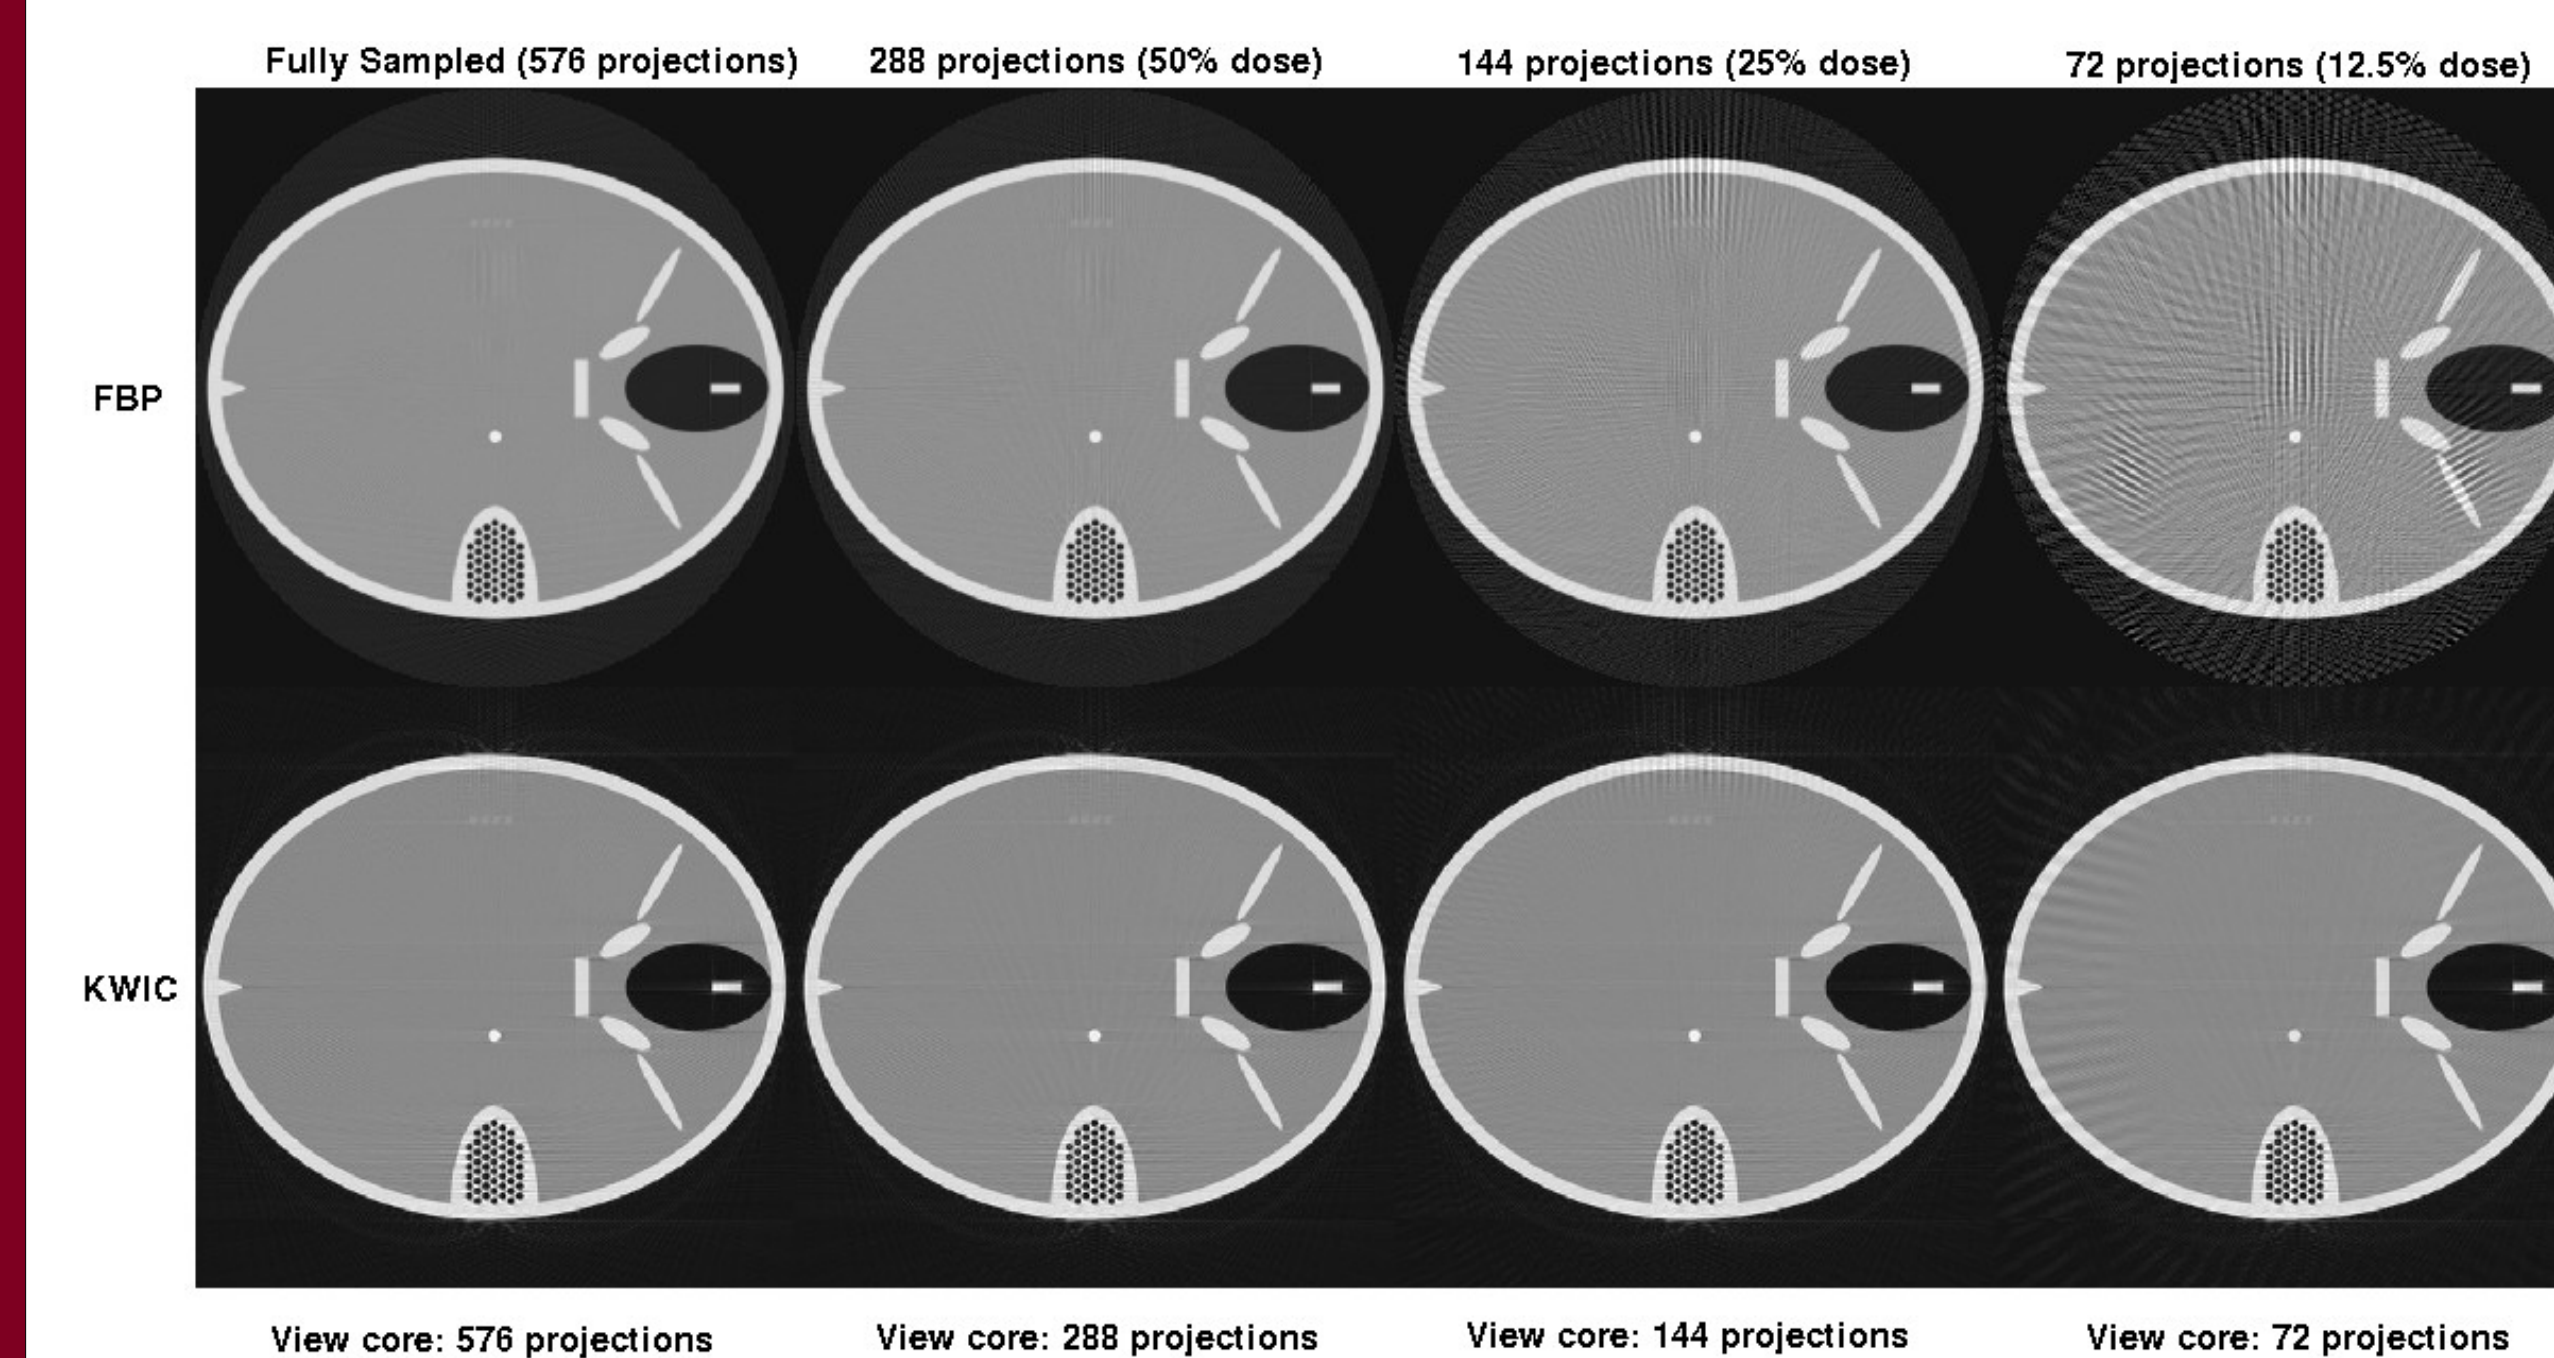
Reconstruction samples for 5 mm object at peak intensity. Note that image quality is preserved using CT-KWIC while aliasing artifacts begin to obscure the FBP image at reduced projections
